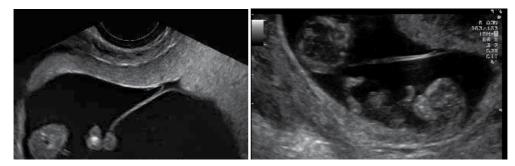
Ultrasound images of a monochorionic diamniotic twin pregnancy. The 'empty' lambda sign or the T sign: only two thin layers of amniotic membranes separate the twins.
